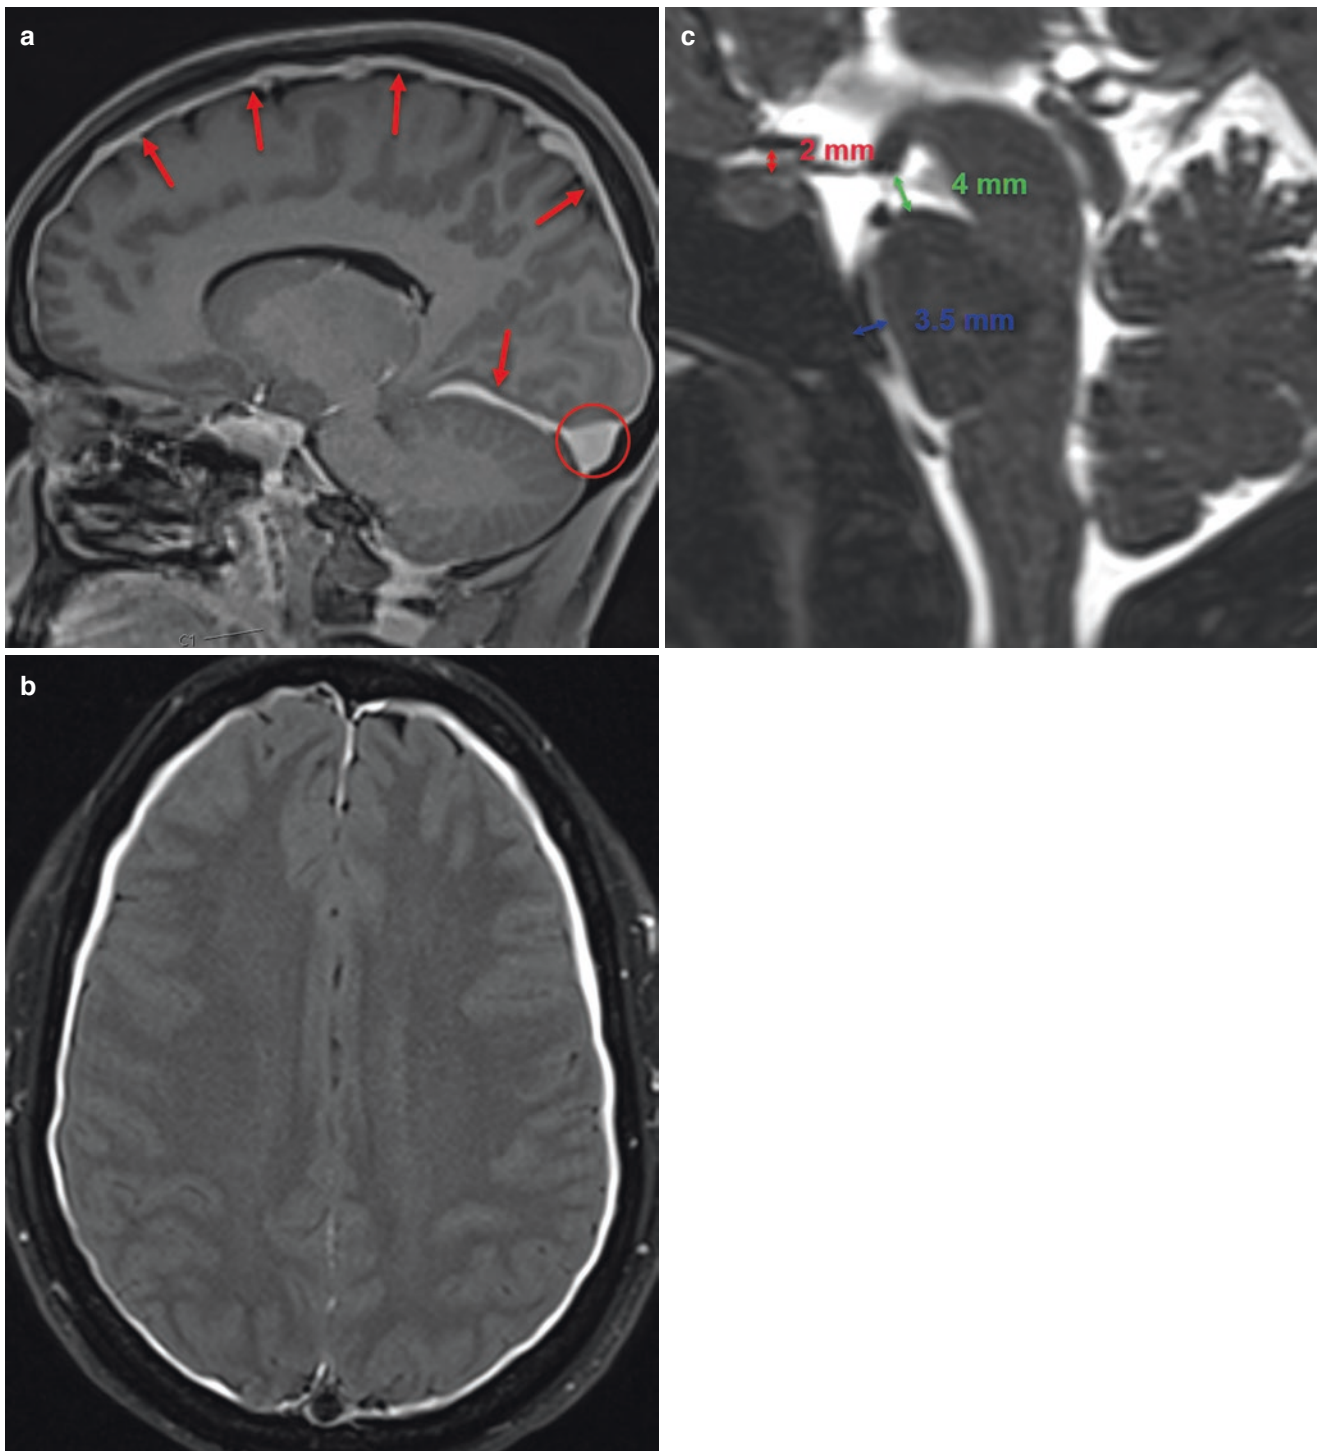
(a) Gadolinium-enhanced brain MRI in the sagittal plane demonstrating homogenous and smooth pachymeningeal enhancement and distension of the transverse sinus. (b) Flair image in the transversal plane demonstrating bilateral subdural collections. (c) T2-weighted
